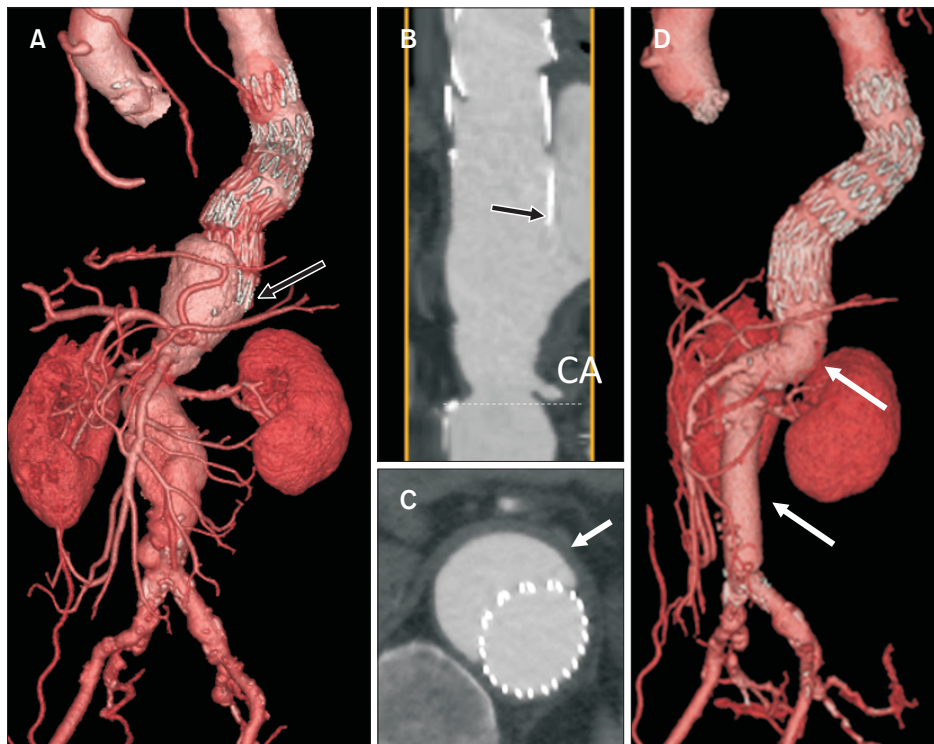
Preoperative three-dimensional computed tomography angiography (3D-CTA) and the initial treatment. (A) Preoperative 3D-CTA demonstrated a Crawford extent I thoracoabdominal aortic aneurysm (arrow). (B) There was not a sufficient distal landing zone above the celiac artery (CA) to place a stent graft (SG). Only 7-mm space between the CA and superior mesenteric artery (SMA) was observed. (C) Intraoperative angiography showed type IB endoleaks after the first SG deployment (arrows). (D) Distal extension with in situ fenestration using Goose Neck Snare (arrow) was deployed to create a distal landing zone. The type IB endoleaks disappeared. rRA, right renal artery.
